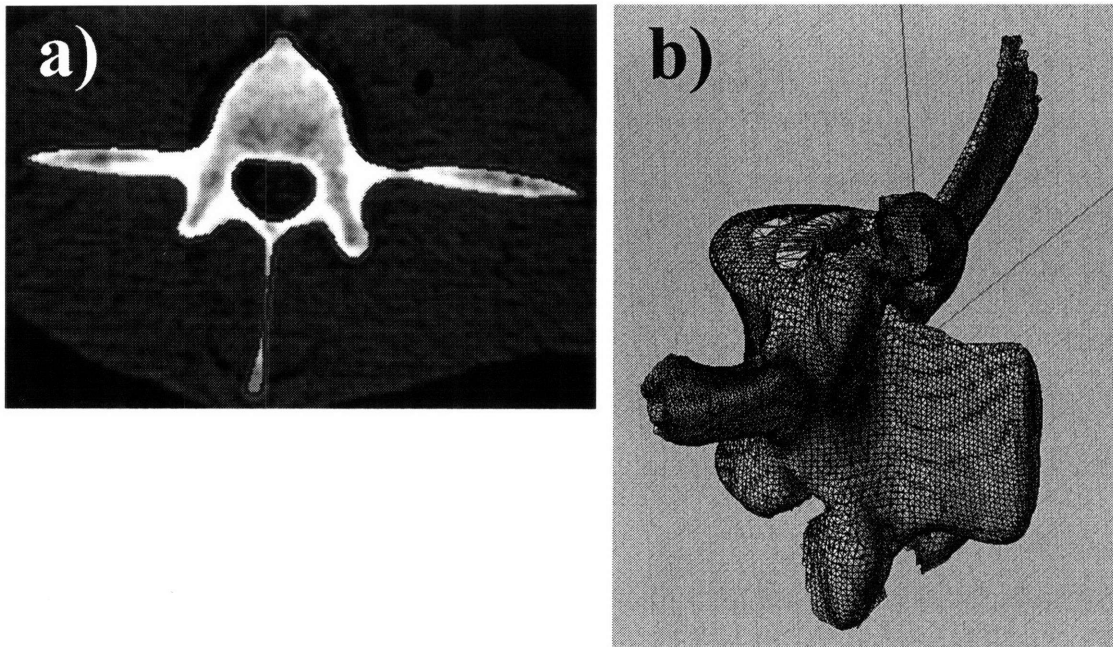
a) Automatic segmentation based on canny edge detection for spine CT scan. b) 3D mesh model constructed from the digitized data.
